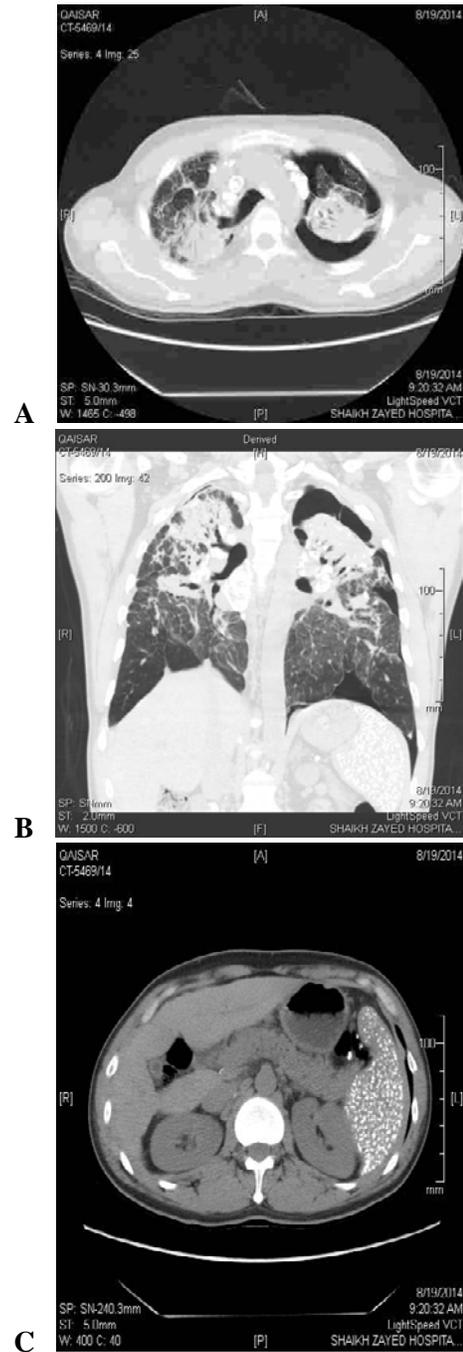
HRCT chest images showing an organized chronic pneumothorax on the left side, bilateral upper lobe fibrotic masses with relative sparing of the lung bases (A and B). Nodular calcification is seen in the spleen (C).
